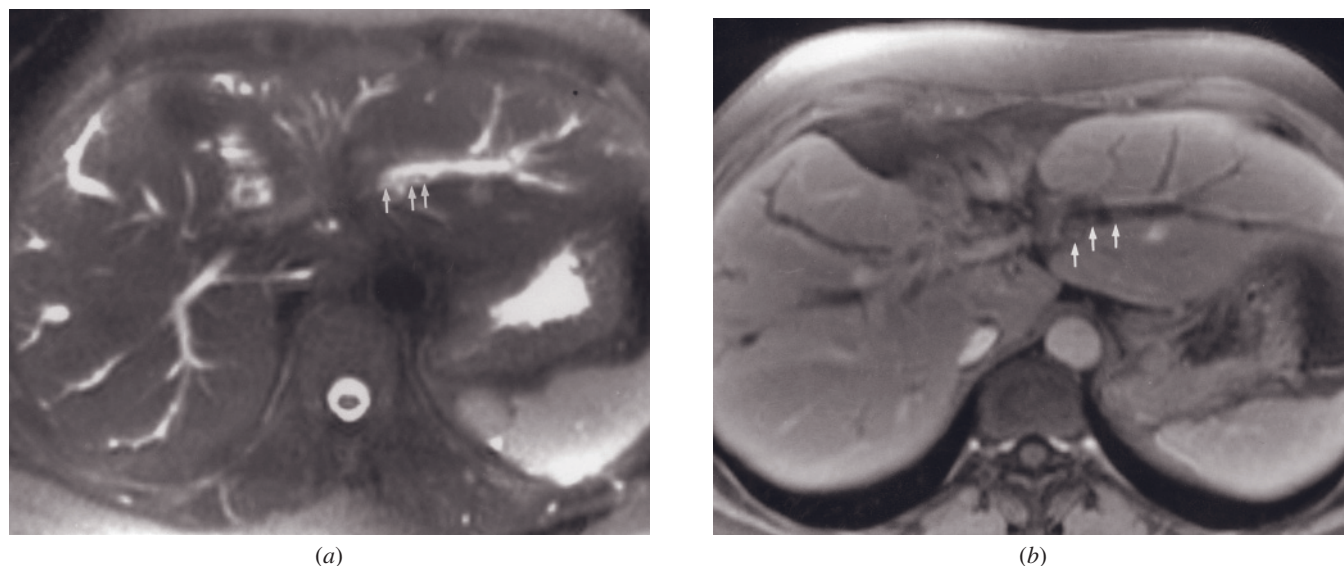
Biliary papillomatosis. T2-weighted single-shot echo-train spin-echo (a) and T1-weighted 2-min postgadolinium fat-suppressed GE (b) images. Several small, biliary intraductal, papillary tumors (arrows, a, b) are revealed showing enhancement on the postgadolinium image (b). The entire biliary tree is moderately dilated because of obstruction by papillomas in the CHD and CBD.
